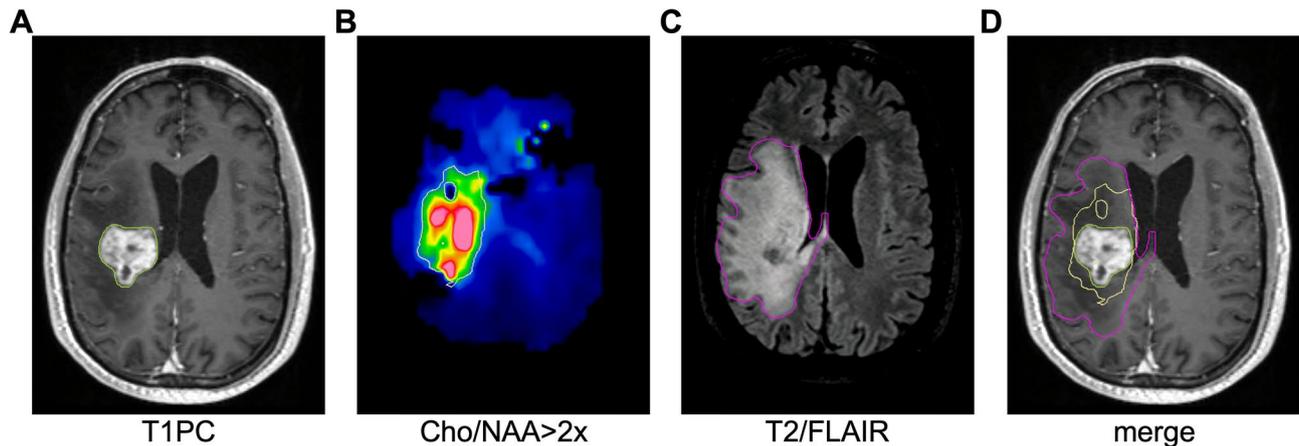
Example contours from a patient with recurrent GBM. A-D. Example contours for a patient with rGBM show T1PC, Cho/NAA > 2x, and T2/FLAIR volumes. Merge image shows extension of Cho/NAA > 2x outside of the T1PC-defined volume but within the T2/FLAIR volume
